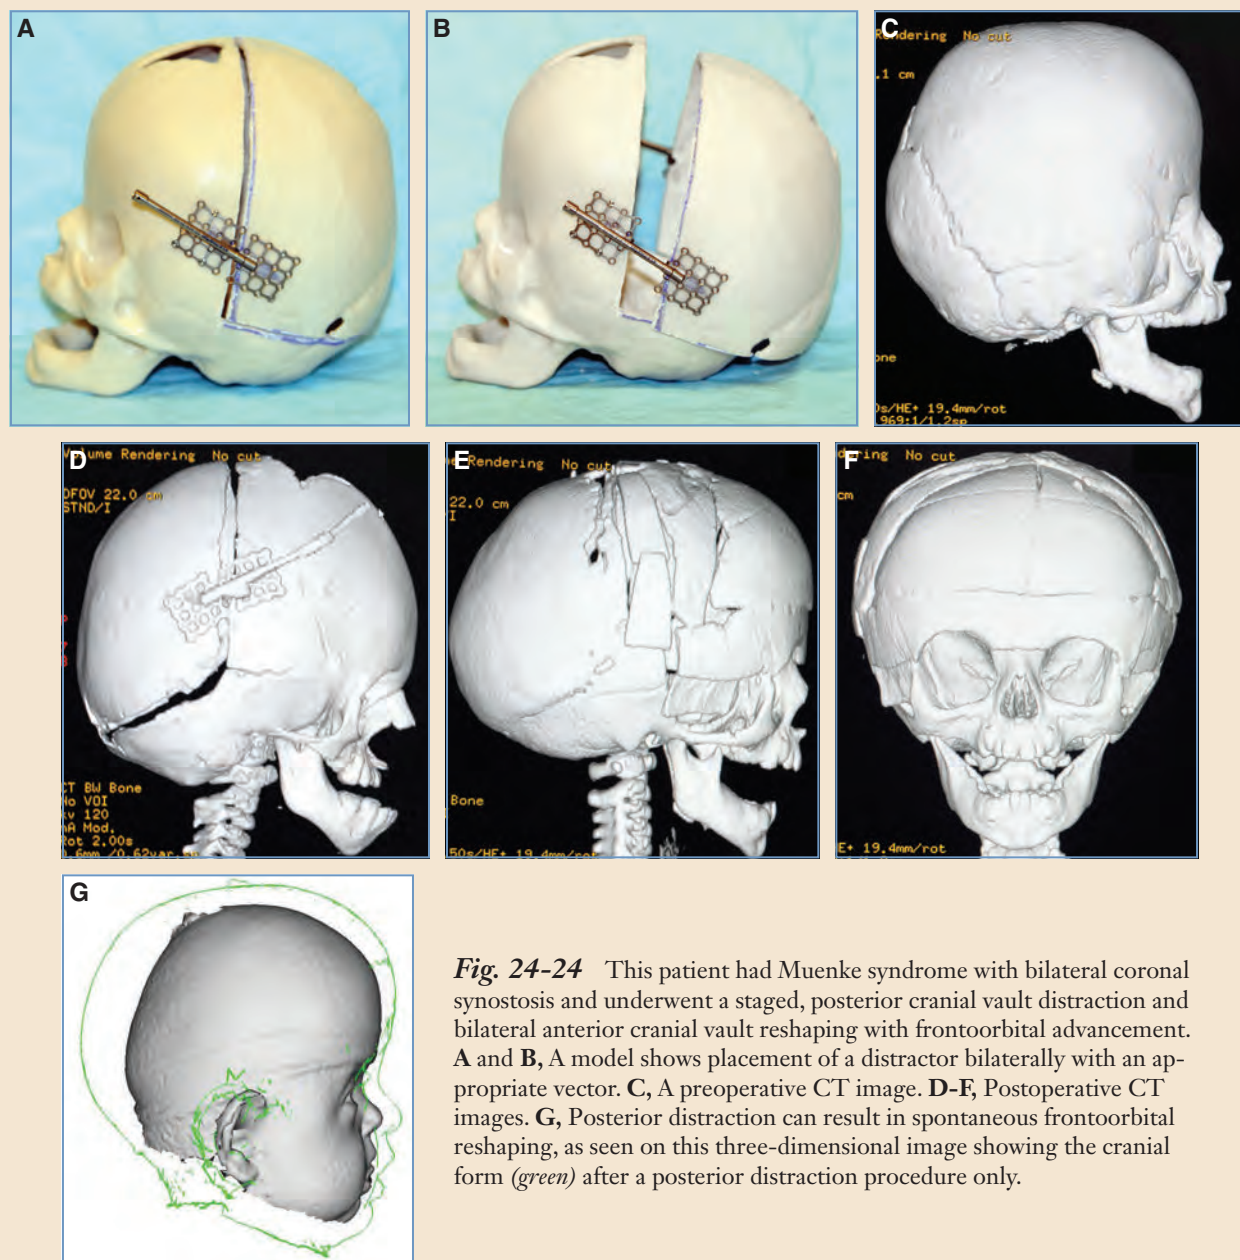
This patient had Muenke syndrome with bilateral coronal synostosis and underwent a staged, posterior cranial vault distraction and bilateral anterior cranial vault reshaping with frontoorbital advancement. A and B, A model shows placement of a distractor bilaterally with an appropriate vector. C, A preoperative CT image. D-F, Postoperative CT images. G, Posterior distraction can result in spontaneous frontoorbital reshaping, as seen on this three-dimensional image showing the cranial form (green) after a posterior distraction procedure only.
